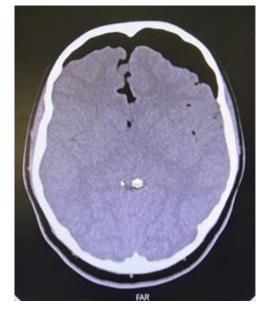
First postoperative brain CT of the patient on the second postoperative day. Pneumocephalus was frankly observed in the frontal area with some compressive effect on the brain
